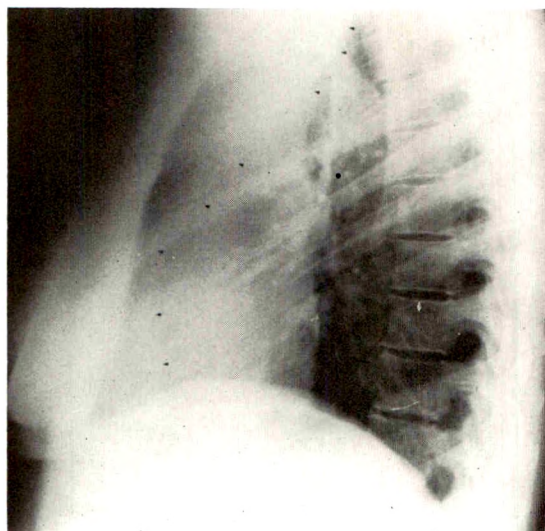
Case II. Left lateral chest roentgenogram showing partial collapse of left upper lobe. There is a faint line of radiodensity running almost parallel to the anterior chest wall (arrows). This represents the partially collapsed and anteriorly displaced left upper lobe.
